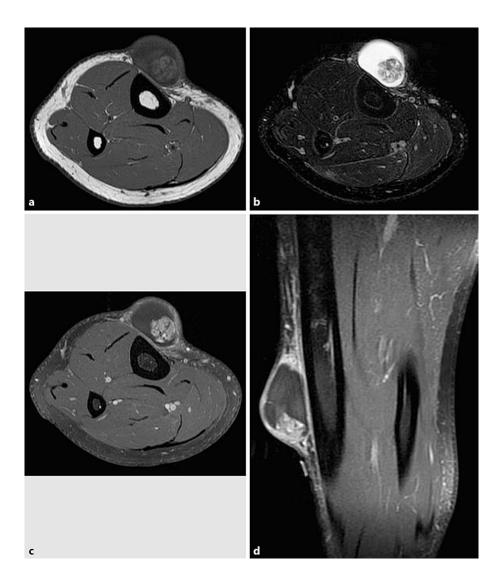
Preoperative MRI of the right lower leg. a Axial T1-weighted image revealed a hypointense lesion with markedly isointense area. b On fat saturation T2-weighted image, the lesion was hyperintense to muscle and contained a heterogeneous area, measuring 1.5×1.5 cm. c, d Postcontrast fat saturation T1-weighted image showed a prominent enhancement of the internal mass and the periphery of the lesion.
